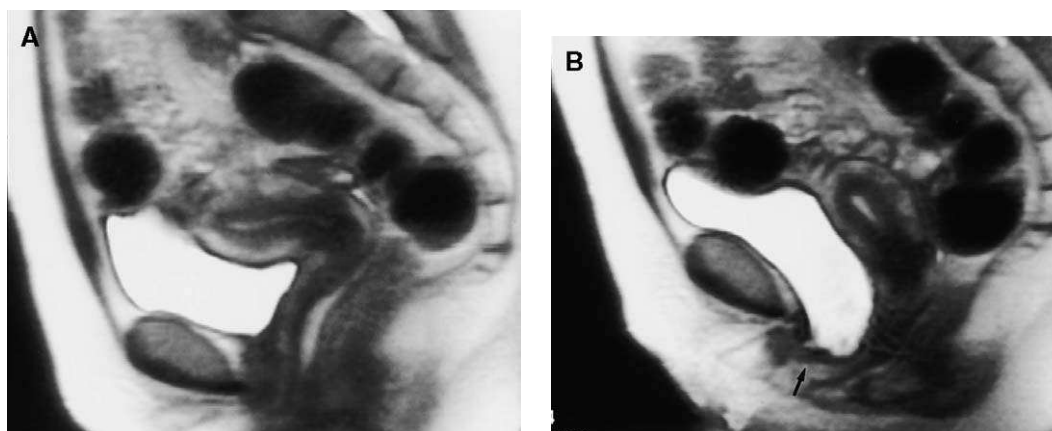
Stress incontinence and incomplete bladder emptying in a 55-year-old woman. Sagittal T2-weighted images (2200/96) at rest (A) and at strain (B) show significant descent of the bladder, with rotation of the urethra into the horizontal plane (arrow) with strain. This may mask stress incontinence. (From Fielding JR. Practical MR imaging of female pelvic floor weakness. Radiographics 2002;22:295–304; with permission.)
